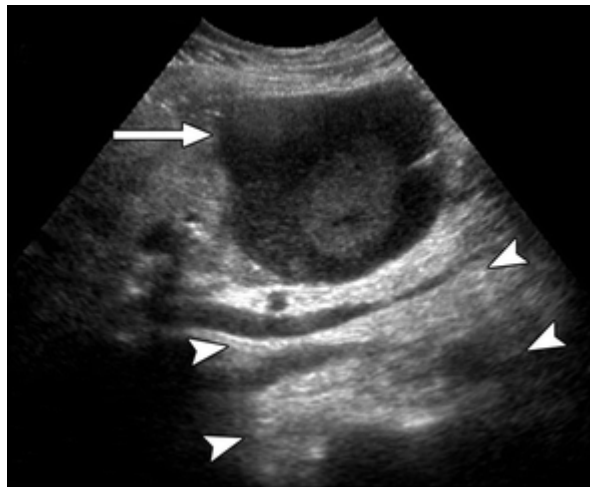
Hemorrhagic hepatic cyst in 78-year-old woman. Transverse ultrasound image shows left lobe hepatic cyst with hypoechoic internal contents (arrow) and increased through-transmission of sound (arrowheads). (www.ajronline.org/27/9/2014 at 5:00pm)
